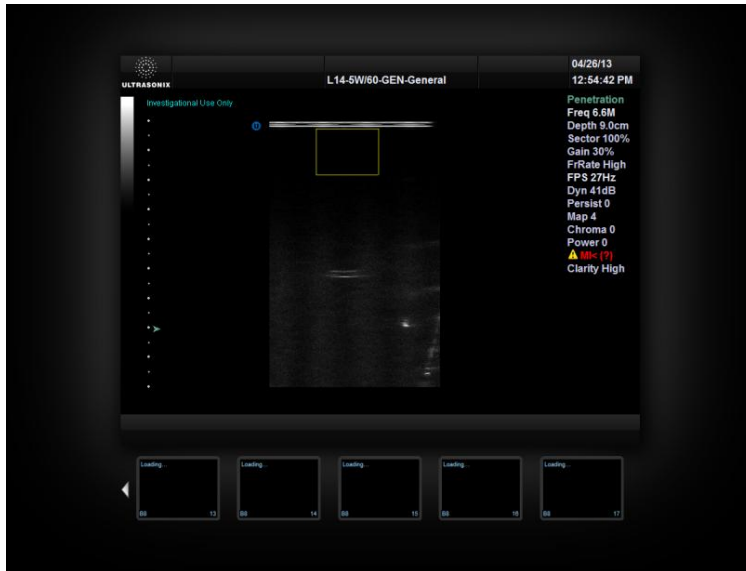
Screenshot of main settings for ultrasound calibration image acquisition
